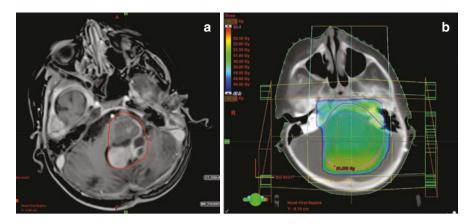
(a) T1 Contrast enhanced axial section of magnetic resonance imaging showing a large residual tumor involving left half of brainstem and left cerebellar peduncle with solid and cystic areas, patchy enhancement, and mass effect over normal brainstem, fourth ventricle, and cerebellum. (b) Three-dimensional conformal radiotherapy plan for the same patient. A dose of 50.4 gray in 28 fractions is planned to planning target volume
